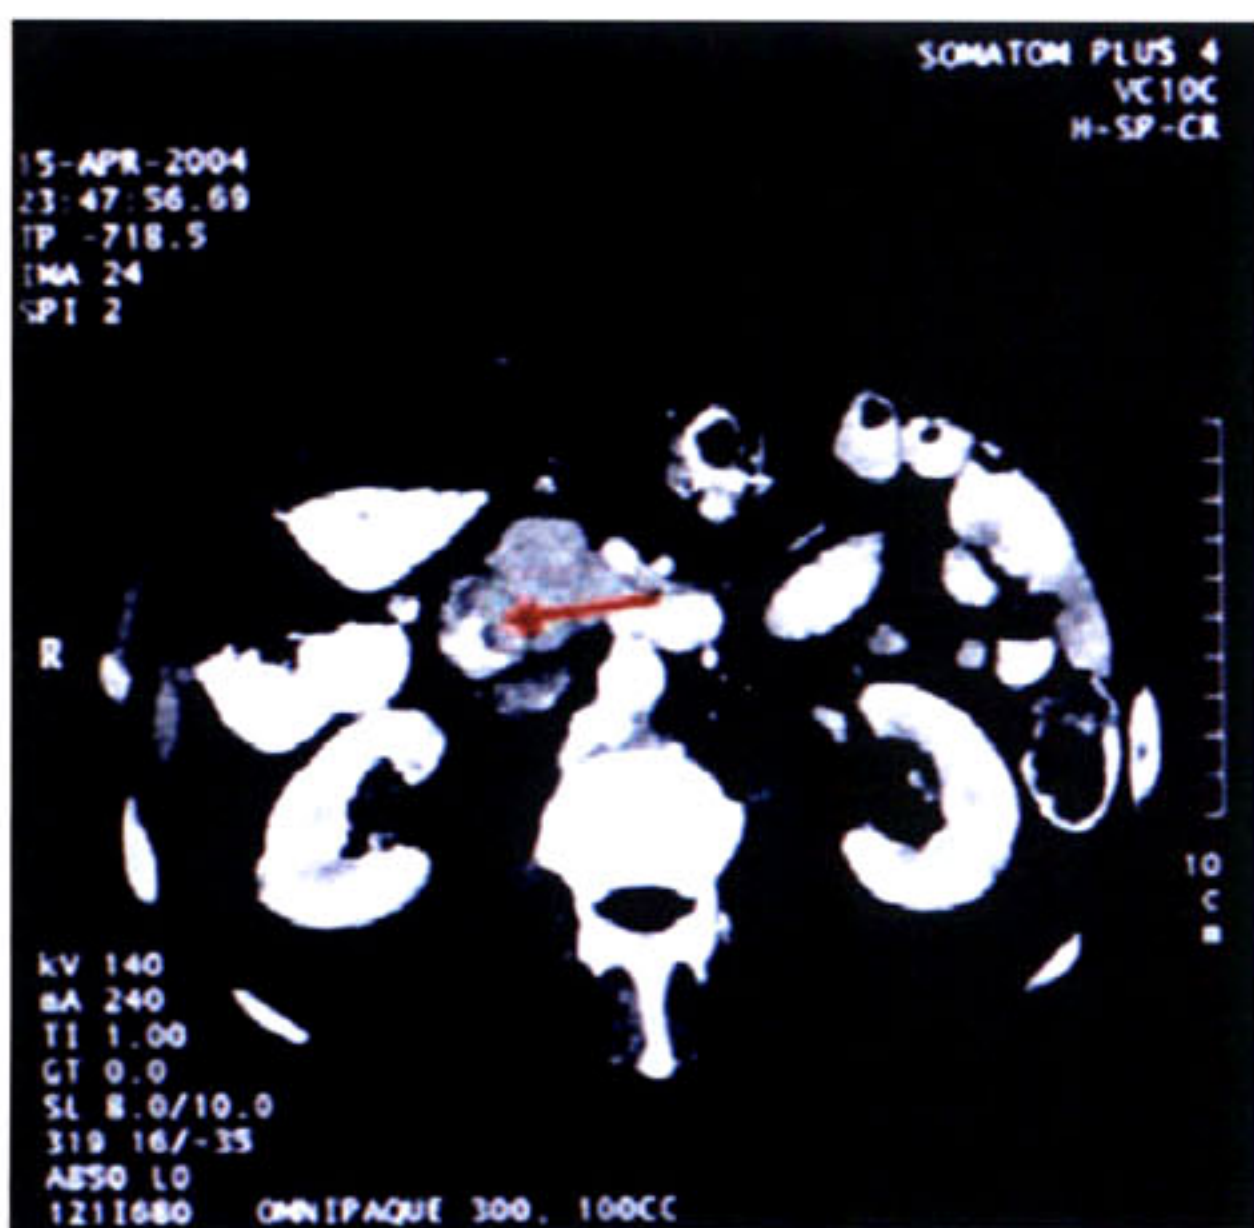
Abdominal CT scan showing partial narrowing of the duodenal lumen. (see arrow)
